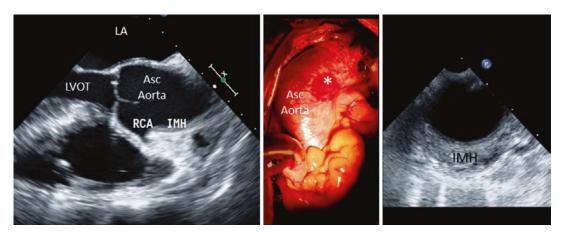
Long axis (left panel) and short axis (right panel) transesophageal echo views of an intramural hematoma, showing central displacement of the intimal layer. The intraoperative photograph of the ascending aorta
